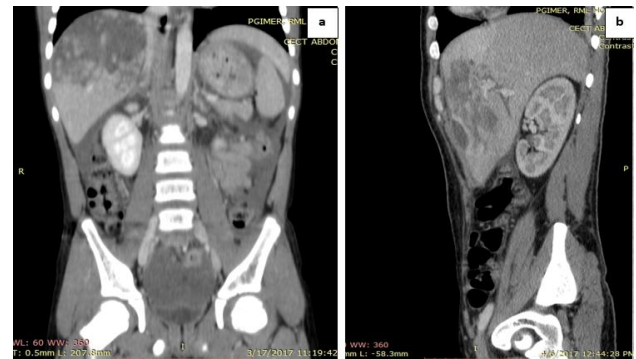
a) and b) Coronal and sagittal reformatted CT of extensive hepatic laceration with hemoperitoneum.
